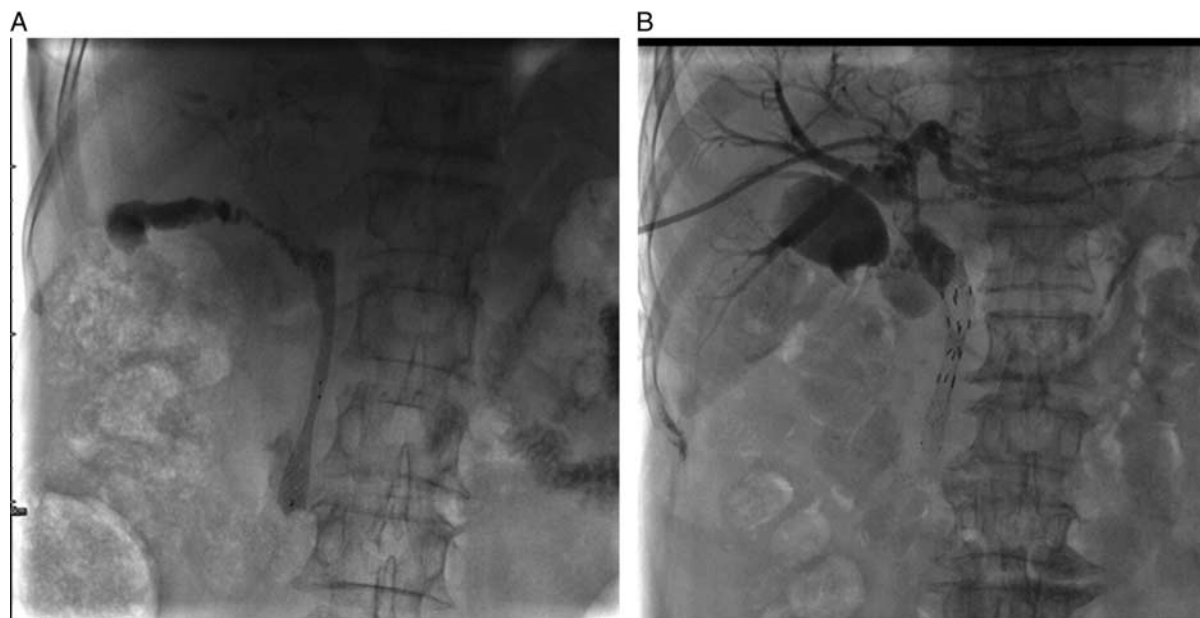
A shows the X-ray image after the placement of conventional biliary stent, and B shows the X-ray image after the placement of radioactive biliary stent.
